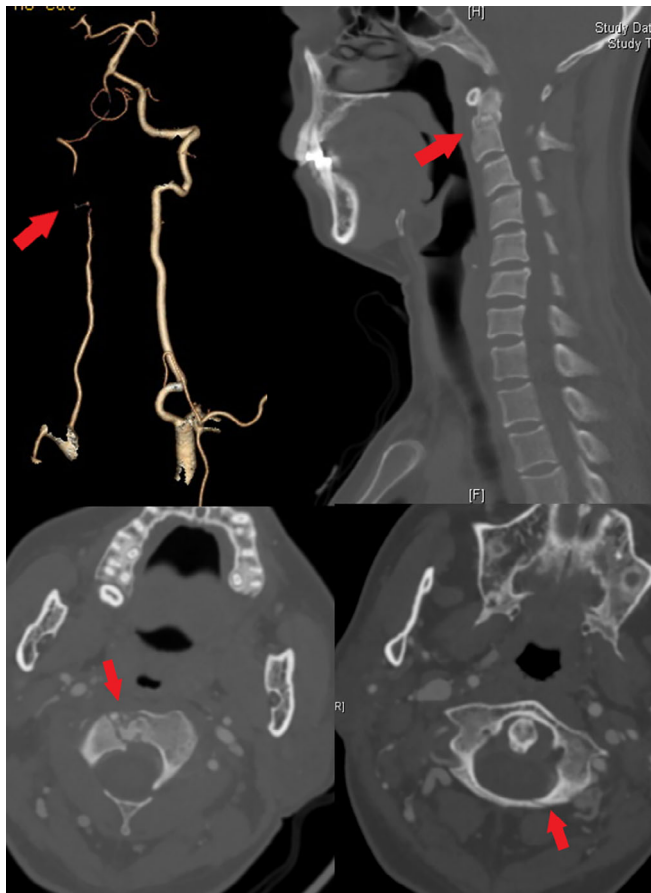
CTA of 6 weeks after injury showed that the fracture line was blurred due to bone formation, but RVAO existed (arrows).
